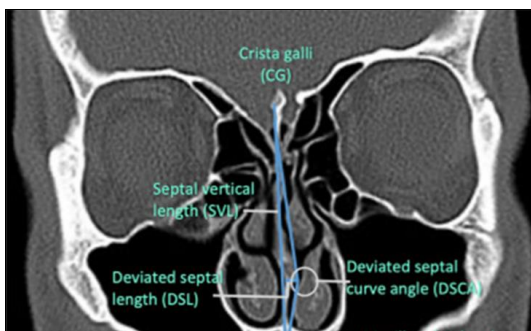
Coronal CT scan shows the methods of measurement of Nasal Septal Deviated Angle
